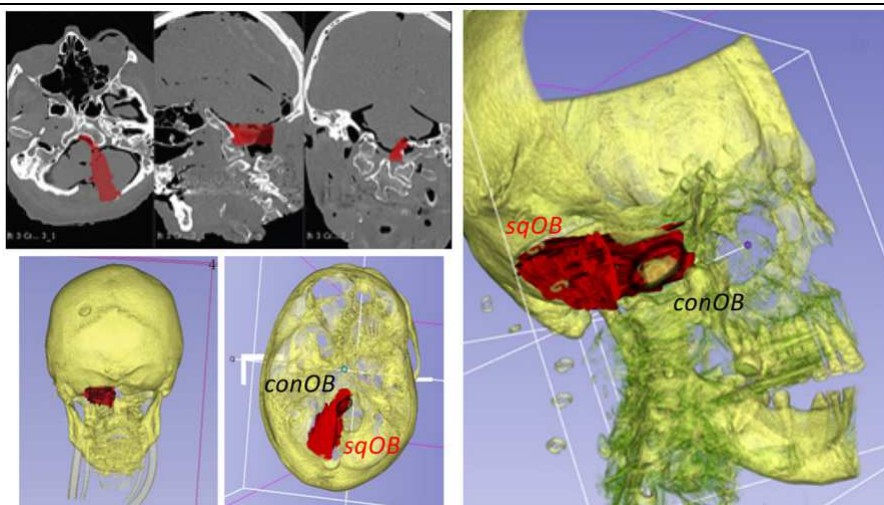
CT-scan with 3D reconstructions of the surgical volume involved in FLA, accessing the foramen magnum posteriorly through resection of the squamous portion of the occipital bone (*sqOB*) and partial resection of the occipital condyle (*conOB*) highlighted in red.
